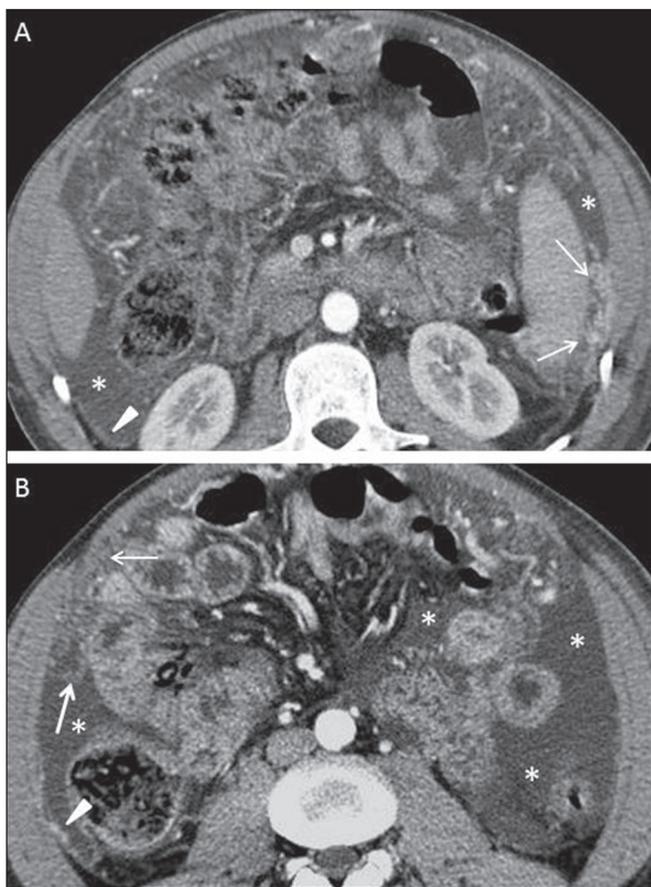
Contrast-enhanced axial CT images of the abdomen. A. Ascites (asterisks) and nodular peritoneal thickening (arrows) may be seen. B. Ascites and enhanced parietal peritoneum (arrowheads); arrows point at the most thickened area of peritoneal fat on the right flank.
